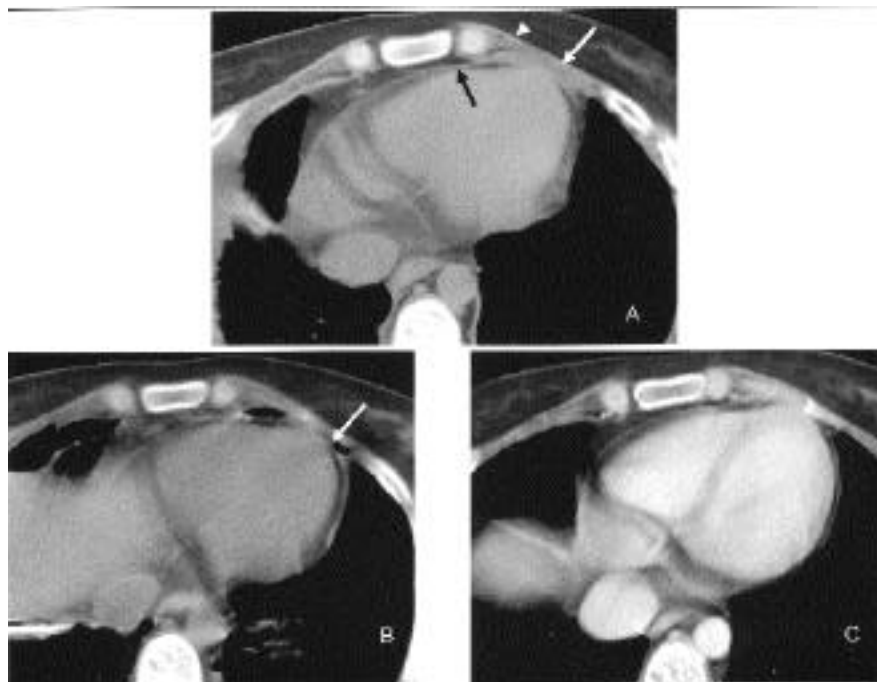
Localized pericarditis on computed tomography (CT). (A) CT at the level of the cardiac apex shows localized effusion between two mildly thickened pericardial layers (white arrows), adjacent to an area of normal pericardium (black arrow). This area is separated from the chest wall (white arrow-head). (B) CT at the level of the cardiac apex, one month prior to admission, demonstrating normal pericardium (white arrow). (C) Contrast enhanced CT scan at the level of the cardiac apex, demonstrating normal pericardium, a year after CT(A) was performed.
